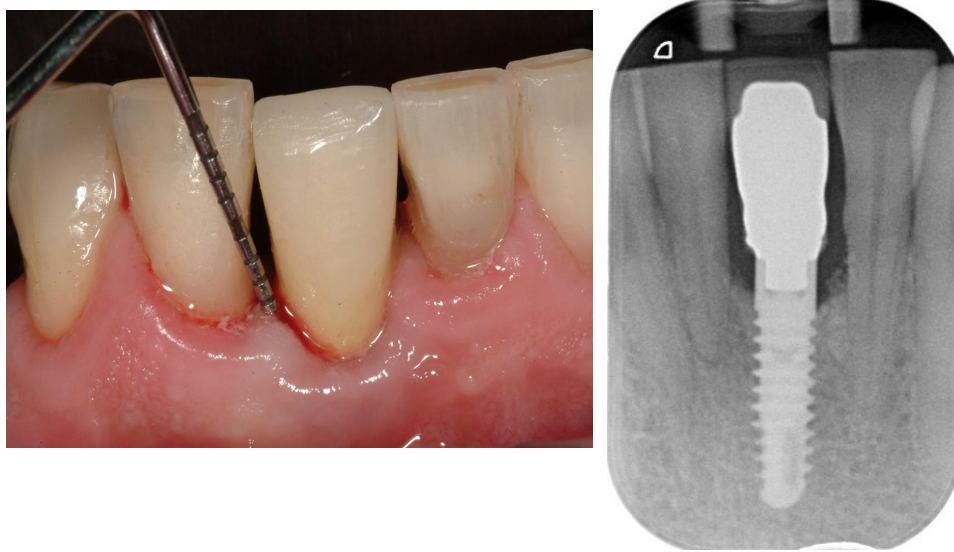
and 2 B: *Photographic and radiographic investigations highlighting the presence of peri-implant mucositis* [Gobbato, L et al.,2013].
